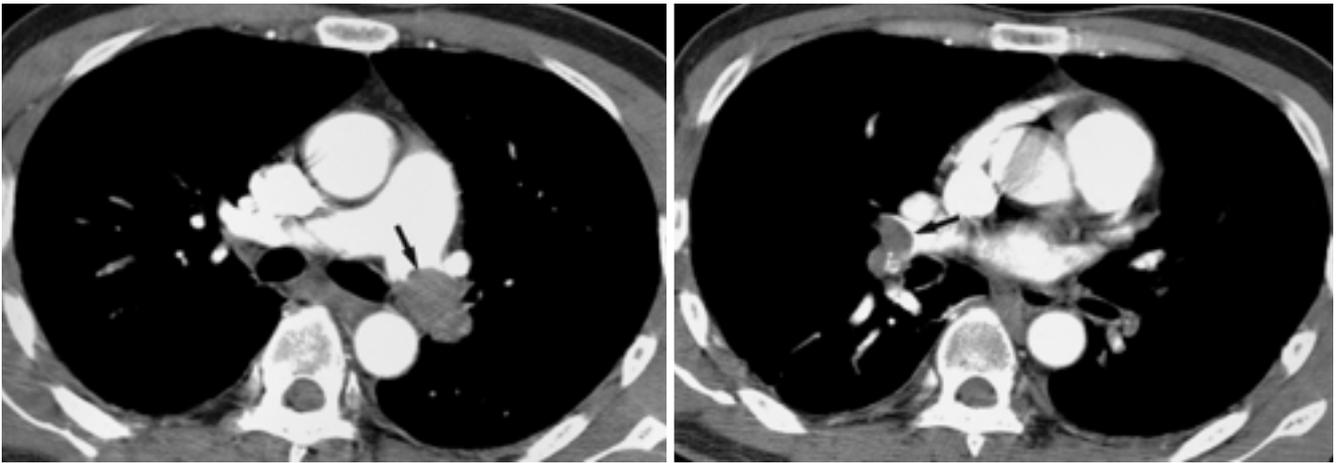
A, B. Contrast-enhanced chest CT with mediastinal setting shows low attenuated lesions (arrows) in both pulmonary arteries.
